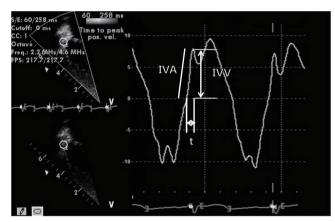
Measurement of isovolumic acceleration (IVA) during isovolumic contraction at the level of the tricuspid annulus using a tissue Doppler echocardiography spectral curve. IVV, peak isovolumic velocity; t, time from zero crossing to peak isovolumic velocity. IVA=IVV/t.
